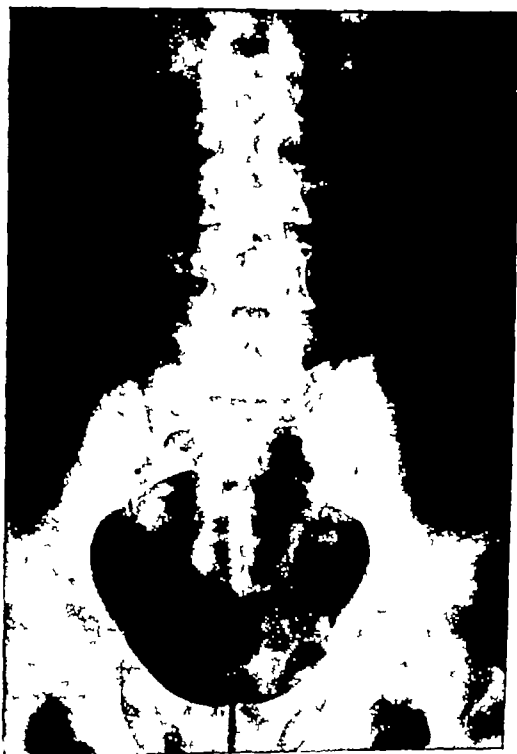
Routine anteroposterior view of case shown in Figure 4. Compare the detail of these two radiographs.
